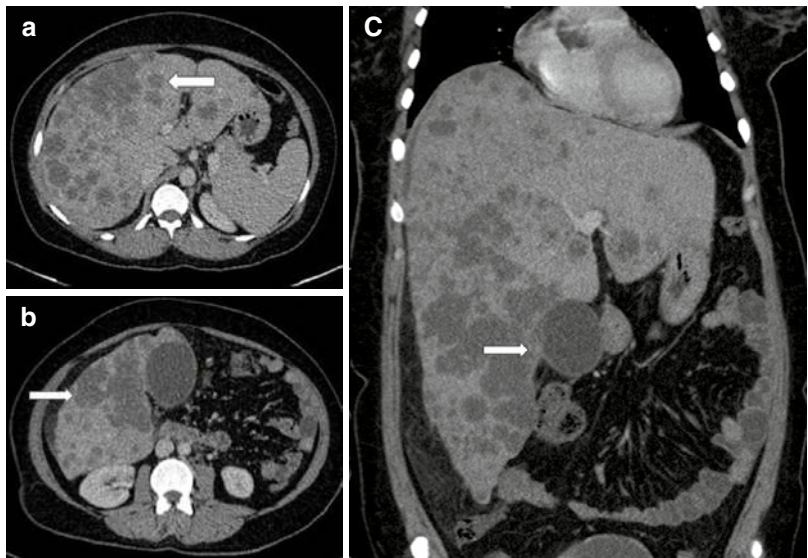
Contrast-enhanced (a–b) axial and (c) coronal reformatted CT scans reveal multiple varying sizes hypoenhancing lesions in both lobes of the liver suggestive of metastases. In addition the confluent mass in segment V is showing loss of fat planes with the gallbladder with associated mild wall thickening (white arrow) in keeping with primary gallbladder carcinoma
